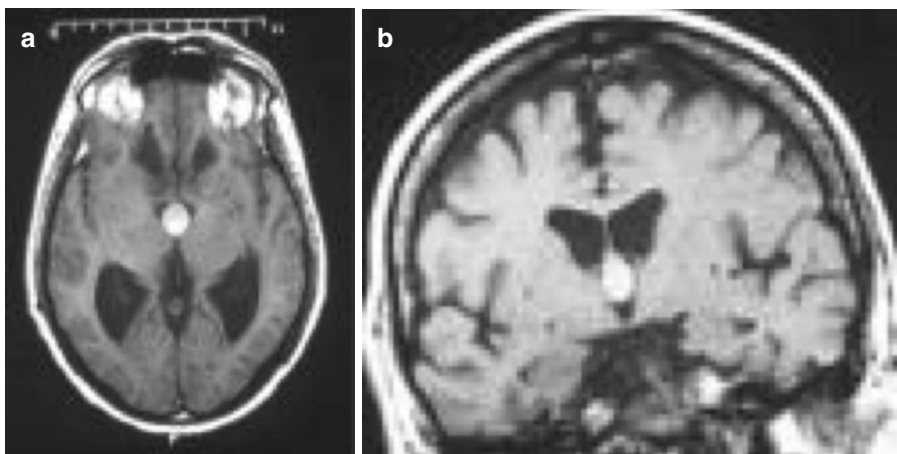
T1 axial and coronal MRI showing colloid cyst
